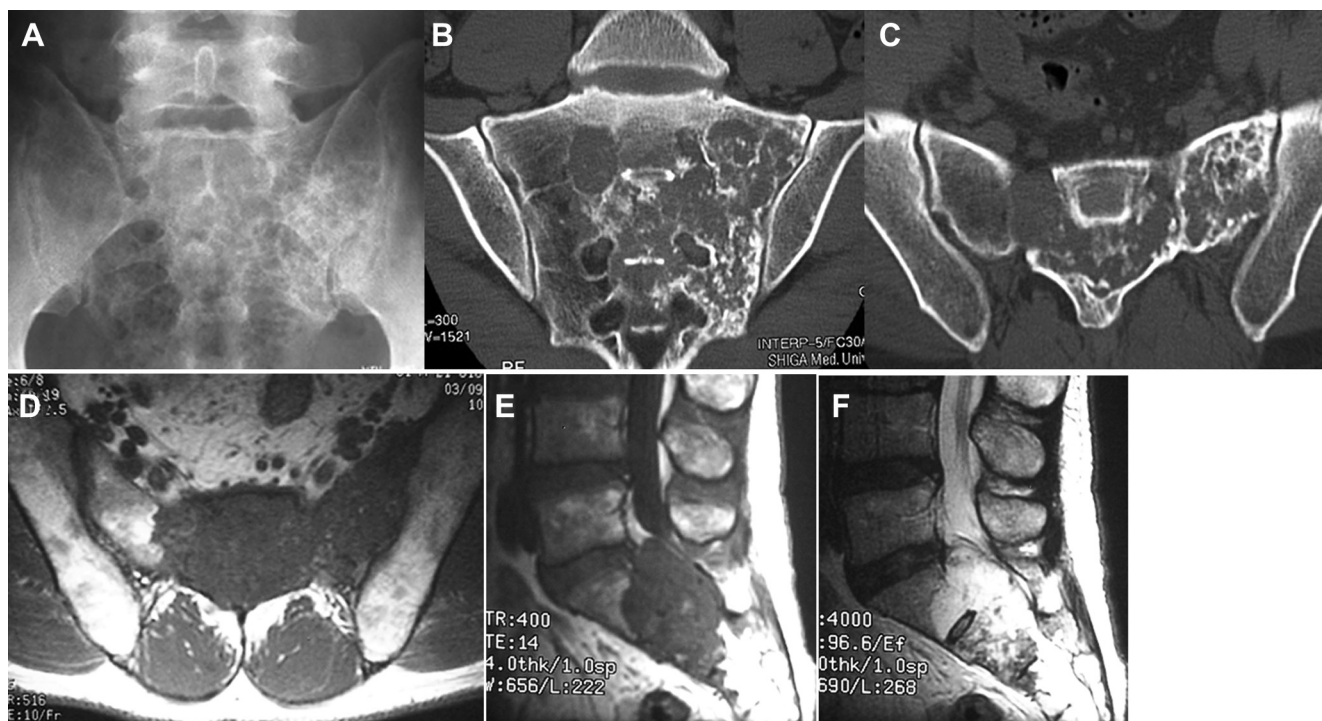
Preoperative images. (A) Plain radiograph and (B and C) computed tomography showed an osteolytic lesion at the sacrum. (D) Magnetic resonance imaging revealed the lesion extended to the sacroiliac joint. (E) The mass showed low signal intensity in T1-weighted images and (F) heterogeneous high signal intensity in T2-weighted images.
